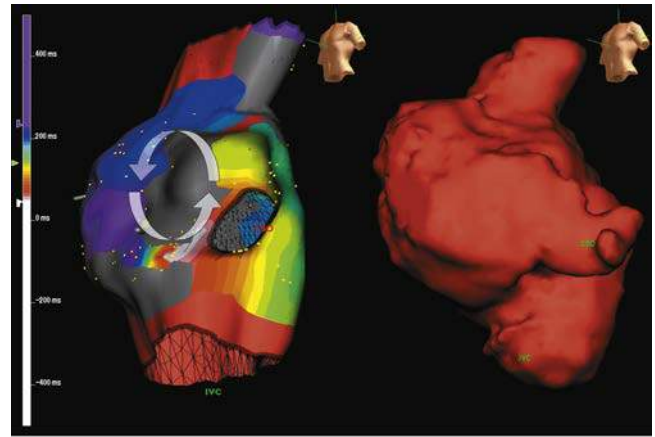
Electroanatomic mapping in a right atrium-to-pulmonary artery Fontan. An electroanatomic map (left) and imported cardiac magnetic resonance image (right) are shown in a patient with a classic modified Fontan and recalcitrant atrial tachyarrhythmias. The gray regions denote areas of dense scar. Local activation times are color-coded, from white to red, orange, yellow, green, light blue, dark blue, and purple. Note the narrow channel of tissue between two dense scars. The arrhythmia circuit propagated counterclockwise around the upper scar and was successfully interrupted by ablating this narrow isthmus. (From Khairy P. EP challenges in adult congenital heart disease. *Heart Rhythm*. 2008; 5:1464-1472.)
